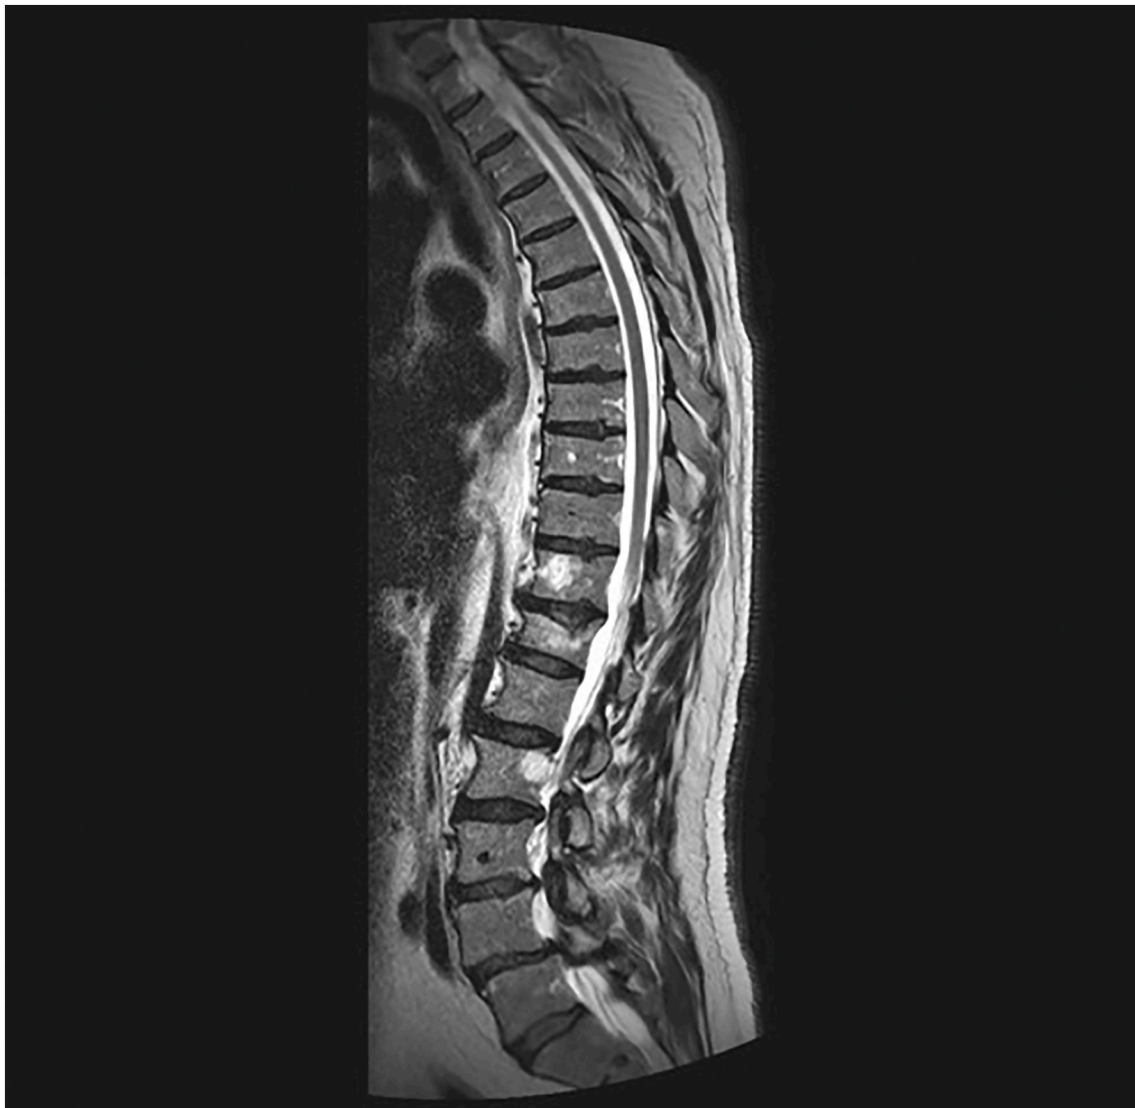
MRI in sagittal projection. An intracanal lesion is seen at the D1 vertebra level; it is hyperintense in the T2-weighted sequence.
